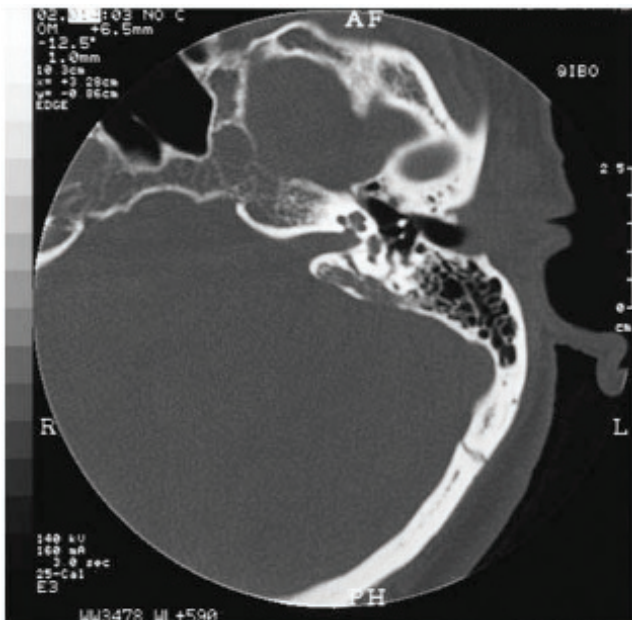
Endolymphatic sac tumour. High resolution axial CT of the temporal bone revealing permeative bone destruction along the posterior margin of the left temporal bone along the line of the vestibular aqueduct. Courtesy of Professor Andy White, Perth Radiological Clinic, Perth, Western Australia.
